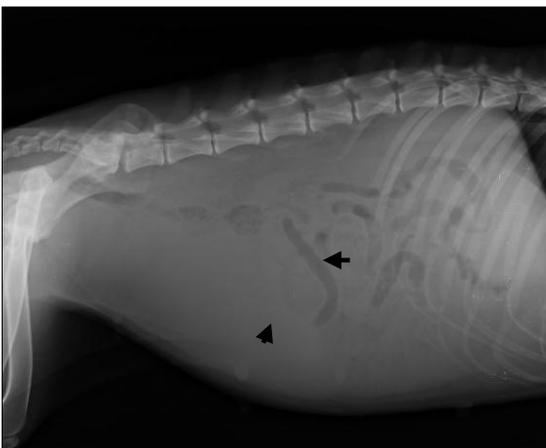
Lateral abdominal radiograph showing ground glass appearance of abdomen
